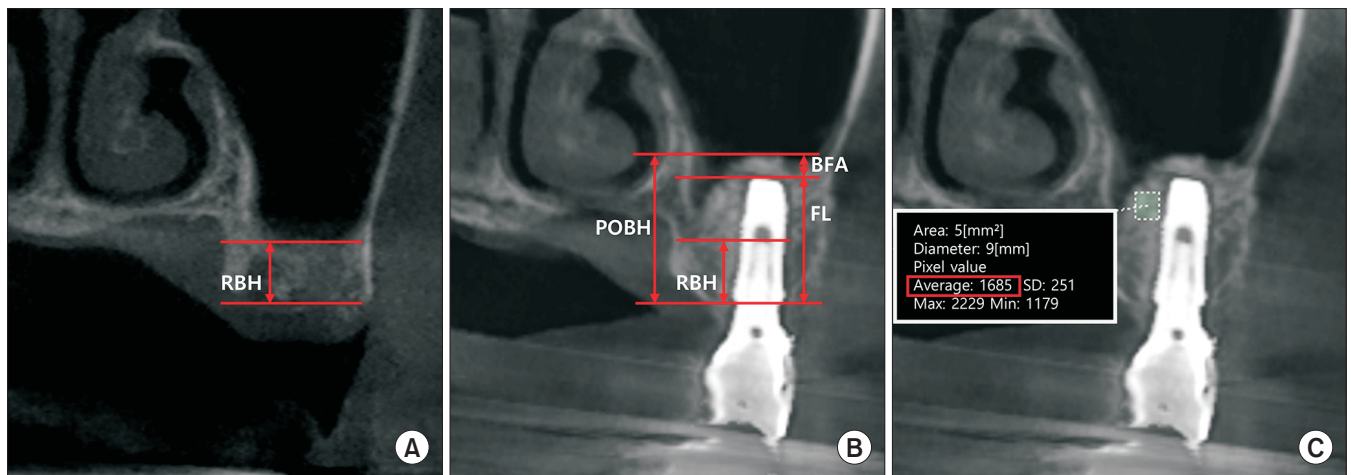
Coronal images on cone-beam computed tomography scans. A. Preoperative height measurement. B. Postoperative height measurement. C. Postoperative bone density. (RBH: residual bone height, POBH: postoperative bone height, FL: fixture length, BFA: bone formation over implant apex)
